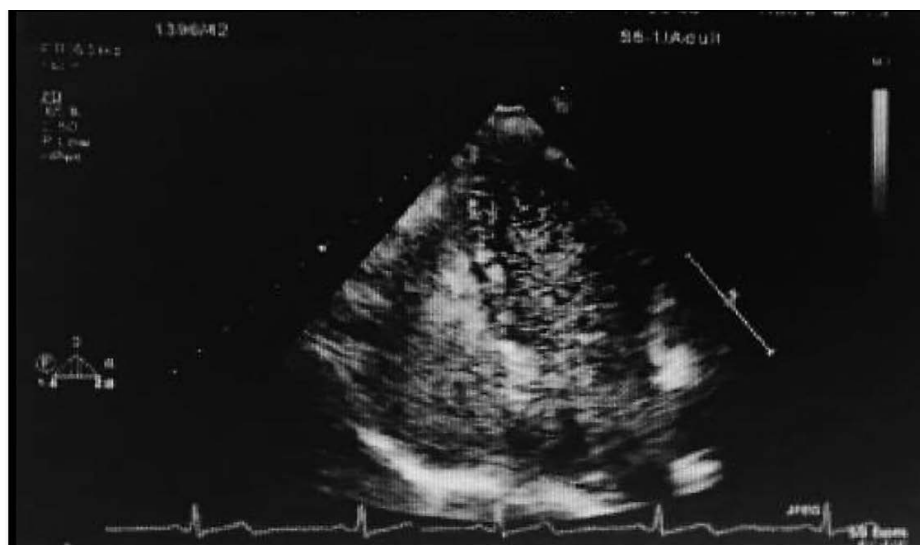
transesophageal echocardiogram revealed numerous microbubbles in the left ventricle.
